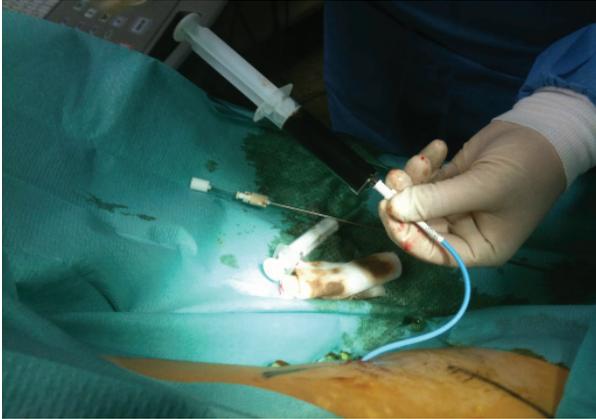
sonographically (with puncture transducer) guided percutaneous insertion of a drainage (here Hydroplus drainage catheter: size 10F, length 29cm), access from left-lateral retroperitoneal
